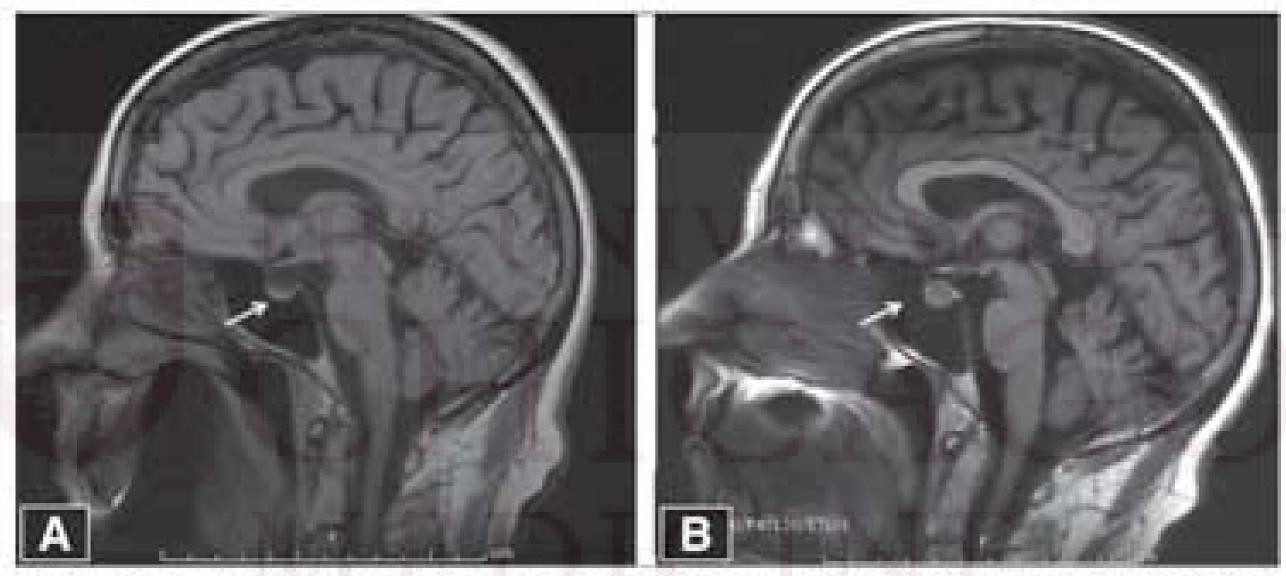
MRI Findings in a Patient With Ipilimumab-Induced Hypophysitis — These MRI images show the pituitary gland before therapy (A) and after four cycles of induction (B).
